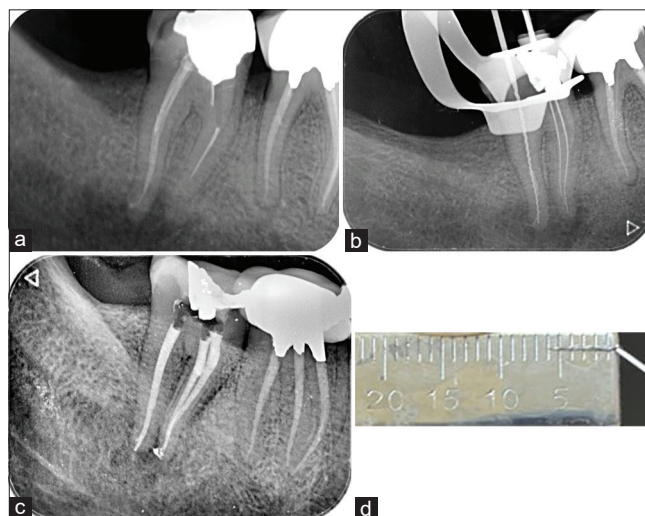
Case 4 with two separated instruments in tooth #31. a) Radiographic examination showing two separated instruments in the MB and ML canals. b) The instruments were retrieved from the canals and confirmed with a radiograph. c) Root canal treatment completed. d) The length of the separated instrument in the MB canal.
